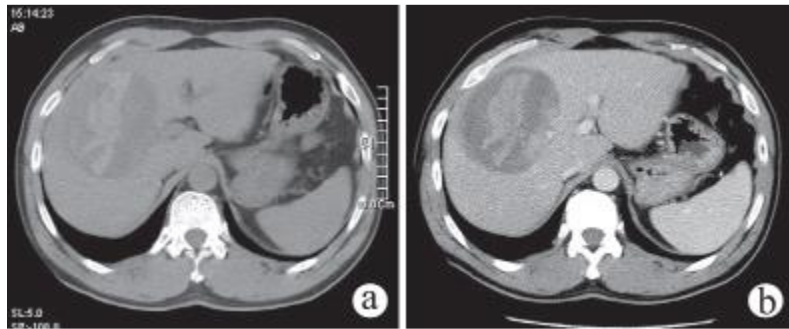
Intratumoral hemorrhage in a poorly differentiated HCC. 48-year-old man with sudden abdominal pain and history of hepatitis B virus infection. US revealed a mixed hyperechogenicity mass in right lobe. (a) Precontrast CT showed a heterogeneous mass with irregular hyperattenuation in the central area. (b) Contrast CT demonstrated no enhancement in either hyperattenuation area or the majority of hypoattenuation area which were proved to be blood products in different stages, a small portion of soft tissue with moderate enhancement could be seen in the left margin on portal venous phase, which proved to be poorly differentiated HCC with intratumoral hemorrhage.
